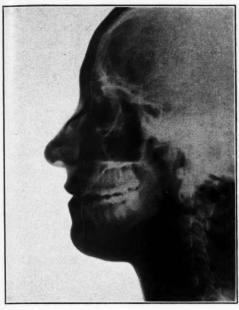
I—Dental profile roentgenogram.
